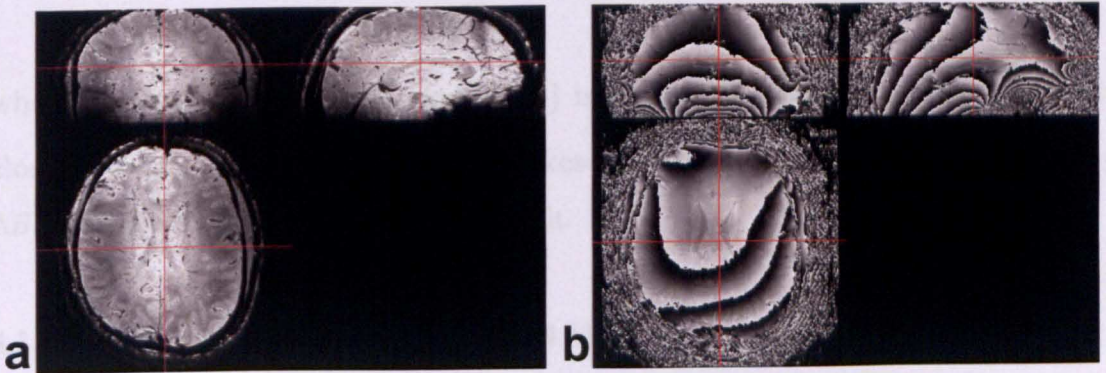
3D MRI data acquired using a FLASH sequence at 7T with TE=15ms. Representative slices in the transverse, coronal, and sagittal planes of the modulus data (a) and phase data (b).
